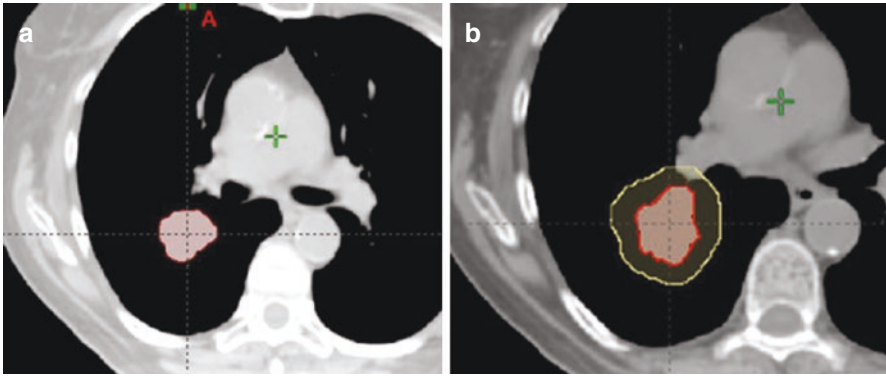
(a) iGTV contour on average CT (or mid-ventilation) dataset with CT numbers overridden to provide a conservative estimate of radiological path lengths throughout the respiratory cycle; (b) uniform expansion to the iCTV
